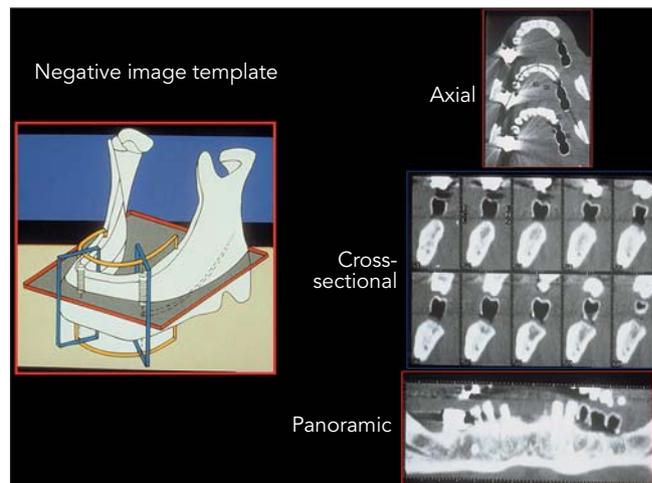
Representation of optimal final tooth positions using a first-generation scanning appliance and noninteractive CT data. Axial, cross-sectional, and panoramic views are shown.
